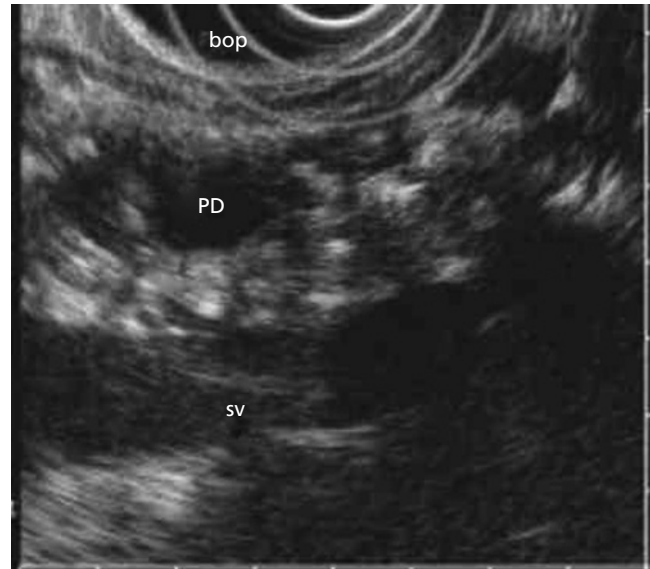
EUS image (7.5 MHz) of chronic calcific pancreatitis in the body of the pancreas using radial endosonography. Multiple hyperechoic foci are present with posterior acoustical shadowing. The pancreatic duct (PD) is dilated. The splenic vein (SV) is posterior to the pancreas.
